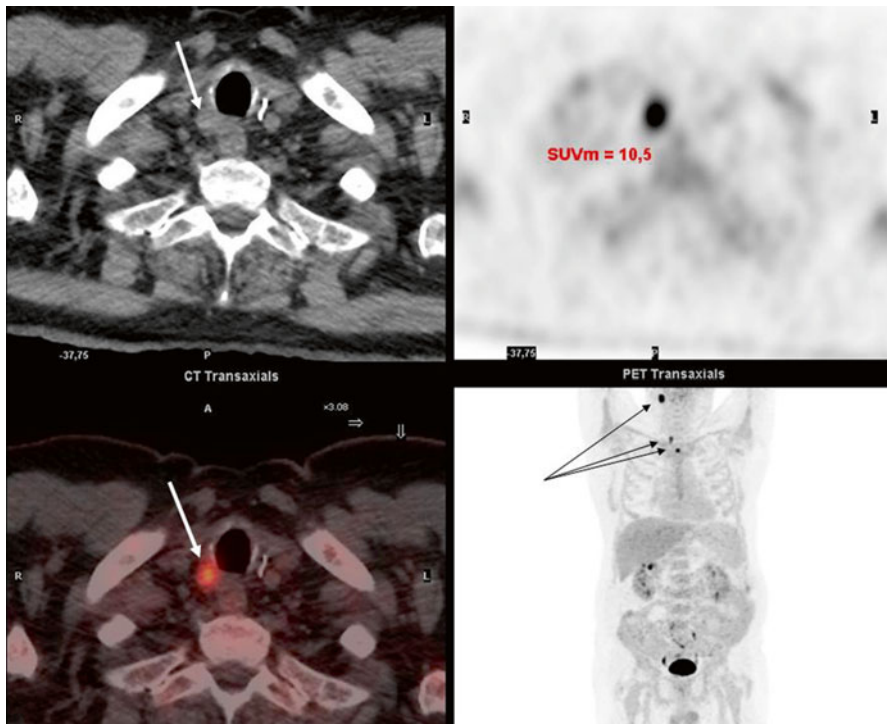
Upper left: non-contrast-enhanced CT showing right paratracheal mass (white arrow). Lower left: ^{18}F FDG-PET-CT showing right paratracheal recurrent tumor (white arrow). Upper right: ^{18}F FDG uptake with a standard uptake value of 10.5. Lower right: ^{18}F FDG-PET showing uptake in three lesions on the right side of the neck—from top to bottom—level II, paratracheal and pretracheal, shown by black arrows
